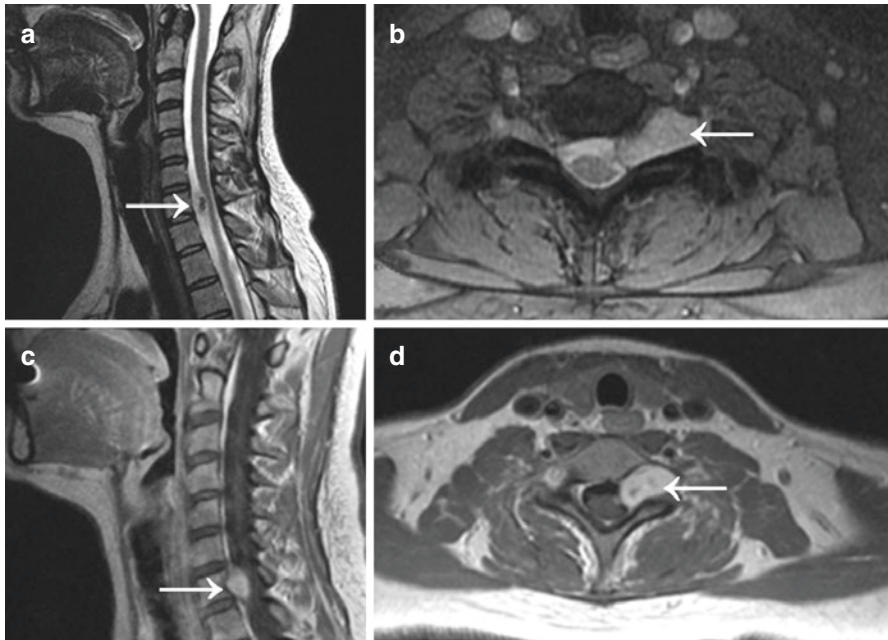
Imaging of a 33-year-old patient with left arm numbness and weakness. (a) Preoperative sagittal and (b) axial T2-weighted MRI of the cervical spine showing hyperintense dumbbell tumor with (c) sagittal and (d) axial T1-weighted post-contrast MRI of the cervical spine demonstrating dumbbell tumor (arrow) with homogenous contrast enhancement at C7/T1 on the left side
